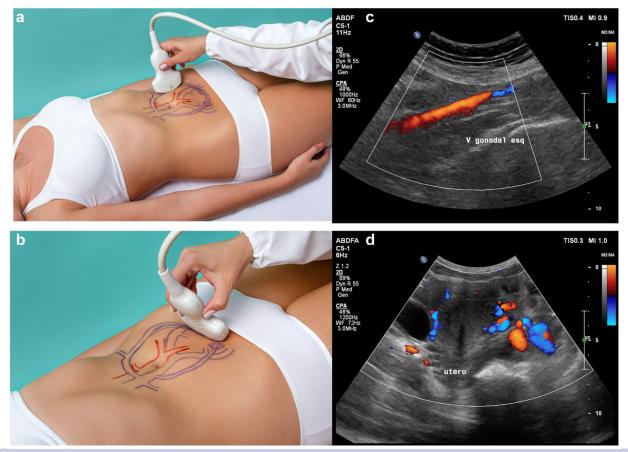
A and B, Location of the left gonadal vein and peri-uterine veins on transabdominal ultrasound examination. C and D, Left gonadal vein and peri-uterine veins on color Doppler. Authors archive.
